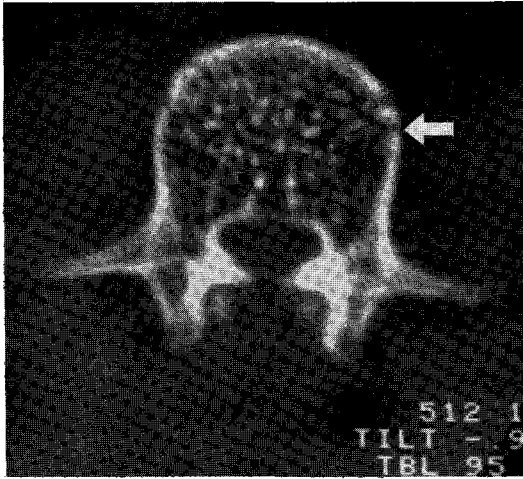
CT scan of L3 shows diffuse involvement of body with honeycomb or polka-dot appearance. Note disrupted cortex (open arrows)
